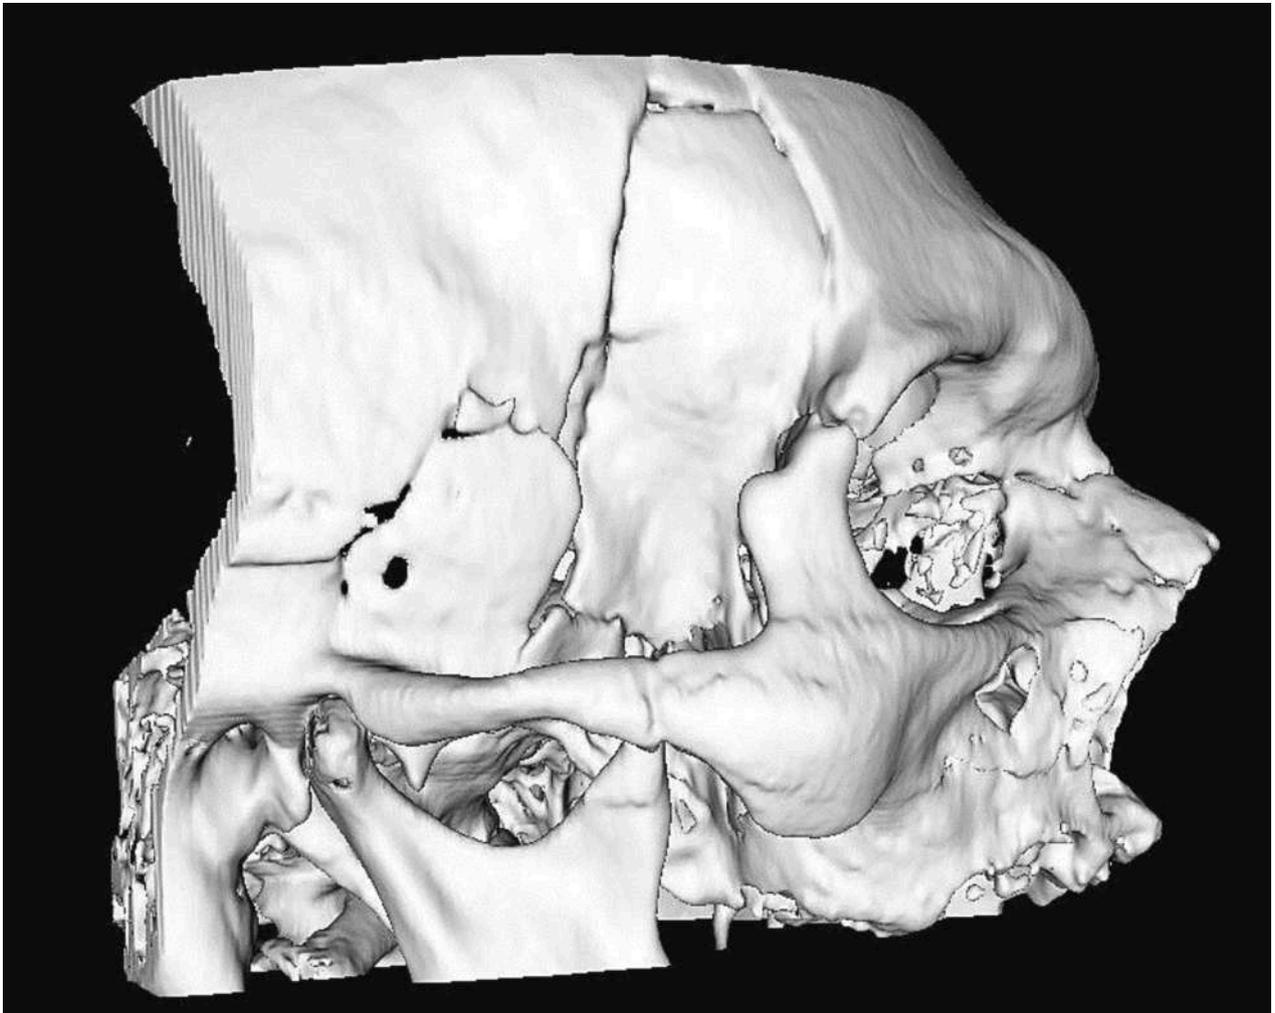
Temporal fractures on postmortem CT scan.
